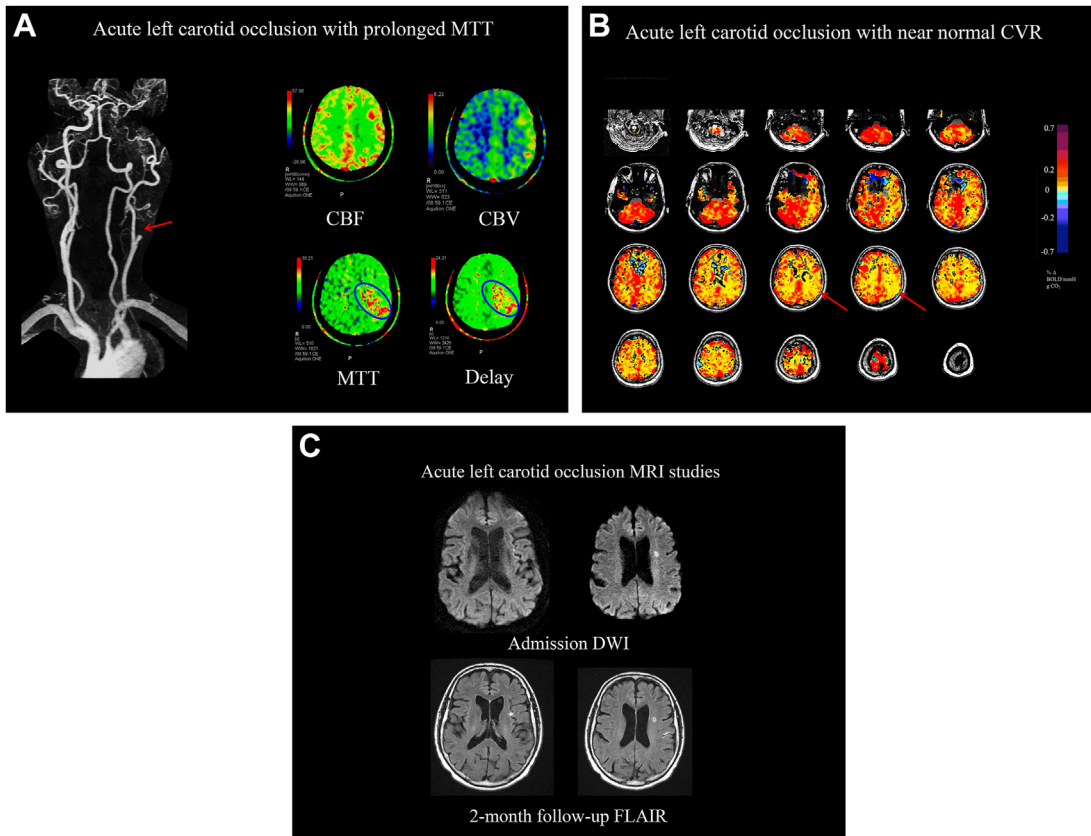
(A) 76 yo patient seen in emergency room (ER) with regular episodes of right-sided facial droop, slurred speech, right sided arm and leg weakness, CTA indicated a left carotid occlusion (*red arrow*) with no string sign. CT perfusion map showed red areas involving left primary motor cortex indicating MTT > 4 sec compared to the remainder of the brain. Heparinization failed to control the TIAs and by-pass surgery was planned. (B) An urgent CVR study revealed near normal hemodynamic reserve (*red arrows*) indicating effective collaterals. The patient was managed conservatively. Symptoms persisted for 10 days and then stopped. The patient was subsequently discharged and continued asymptomatic at 2 month follow-up. Note the consistently higher CVR always seen in the cerebellum and brainstem. (C) MRI indicated only small areas of acute ischemic injury in the left hemisphere on admission with minimal progression on follow-up at 2 months.
